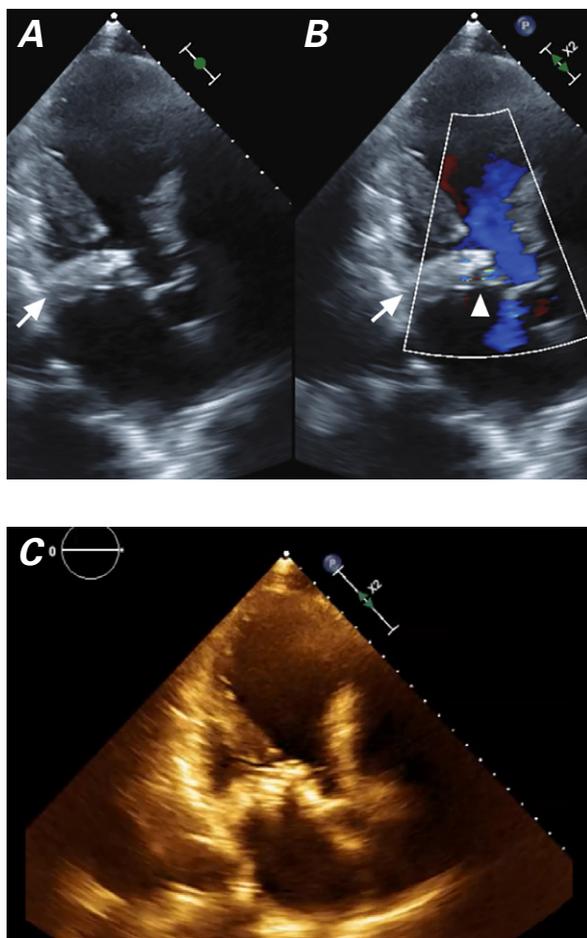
Transthoracic echocardiograms in A) 2-dimensional and B) color-flow Doppler modes obtained at 2-month follow-up show the SAPIEN 3 valve in the mitral position (arrows). There is minimal, if any, paravalvular leak, and the valve is in the correct position (arrowhead). C) Still frame of the echocardiogram obtained at 2-month follow-up.
